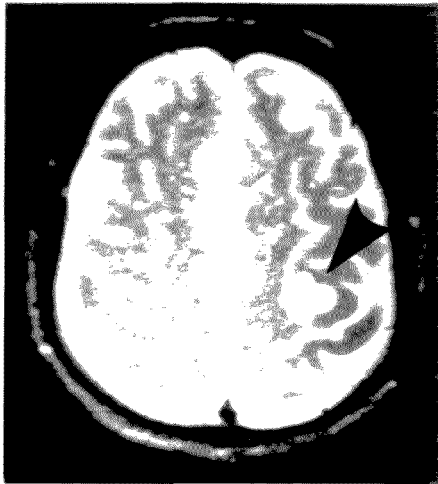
T<sub>2</sub>-weighted magnetic resonance image shows discrete cortical infarct in left frontal area (arrowhead).
